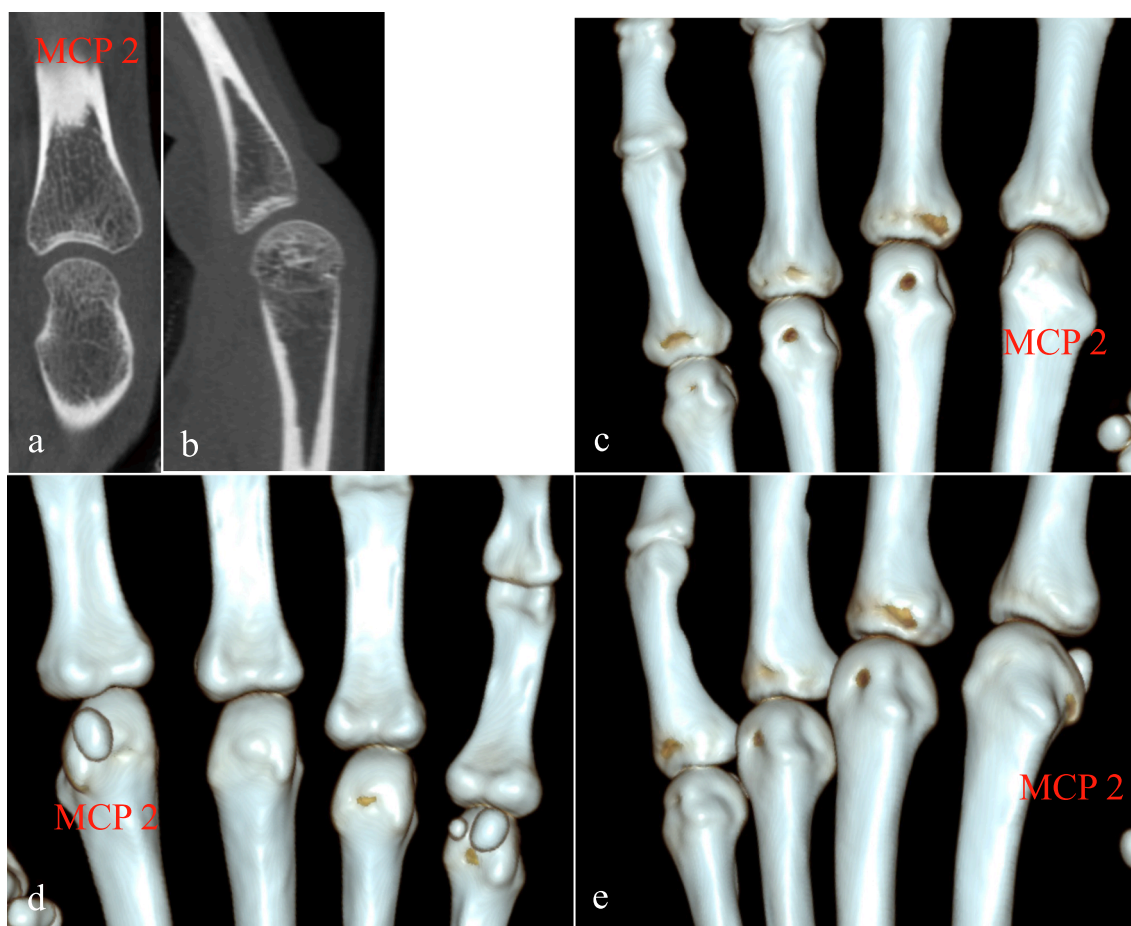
CBCT of the index MCPJ. Coronal view (a), sagittal view (b). CBCT volume rendering reconstructions : dorsal view (c), palmar view (d), oblique view (e).
